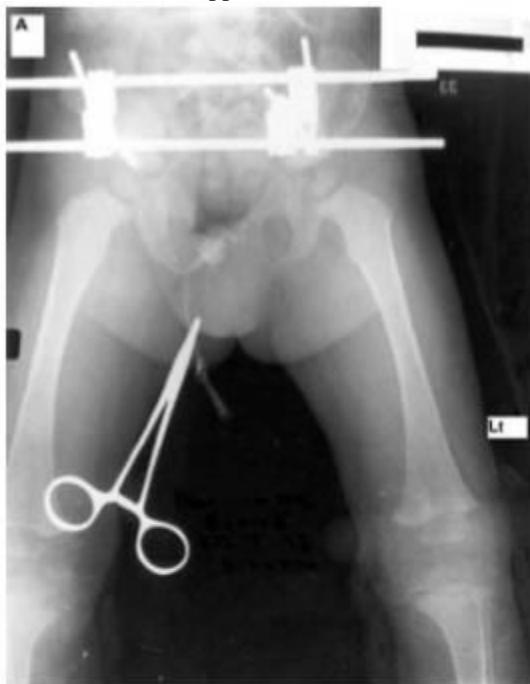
(A) Intra-operative radiograph of a 2 month old boy after the technique of pelvic osteotomy used.
